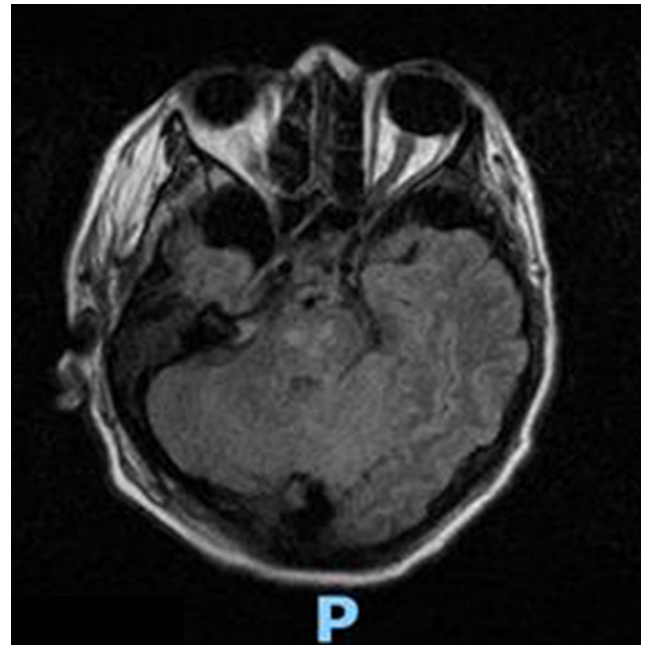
MRI brain-T2 Flair showing pontine hyper intensities.
